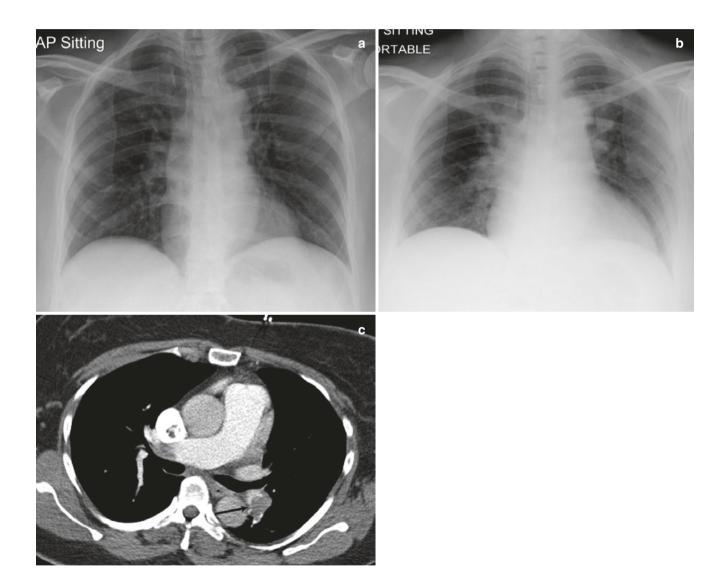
A 50-year-old woman with acute PE. (a) Radiograph obtained 2 months before acute presentation. (b) Frontal radiograph on presentation with sudden-onset dyspnea after a long flight shows new focal oligemia
